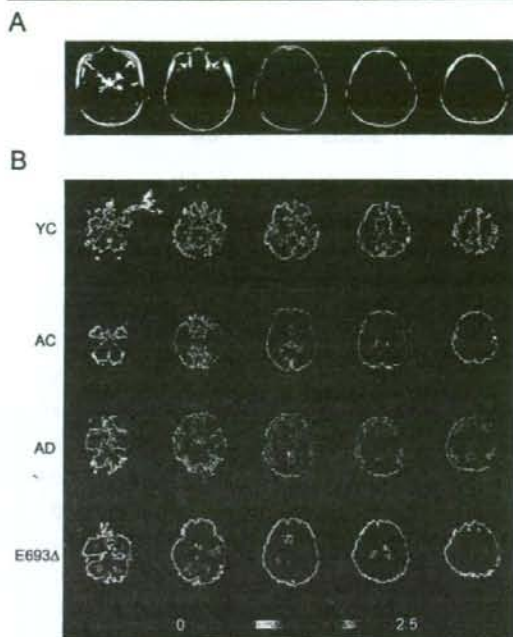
(A) Magnetic resonance imaging of the proband's brain at 62 years old. (B) Amyloid imaging of the proband's brain with [¹¹C] Pittsburgh compound-B (PIB). PIB standardized uptake value images summed over 40 to 60 minutes are shown. YC = young control (29-year-old man); AC = aged control (81-year-old woman); AD = Alzheimer's disease (71-year-old woman); E693 Δ = proband (62-year-old woman).
